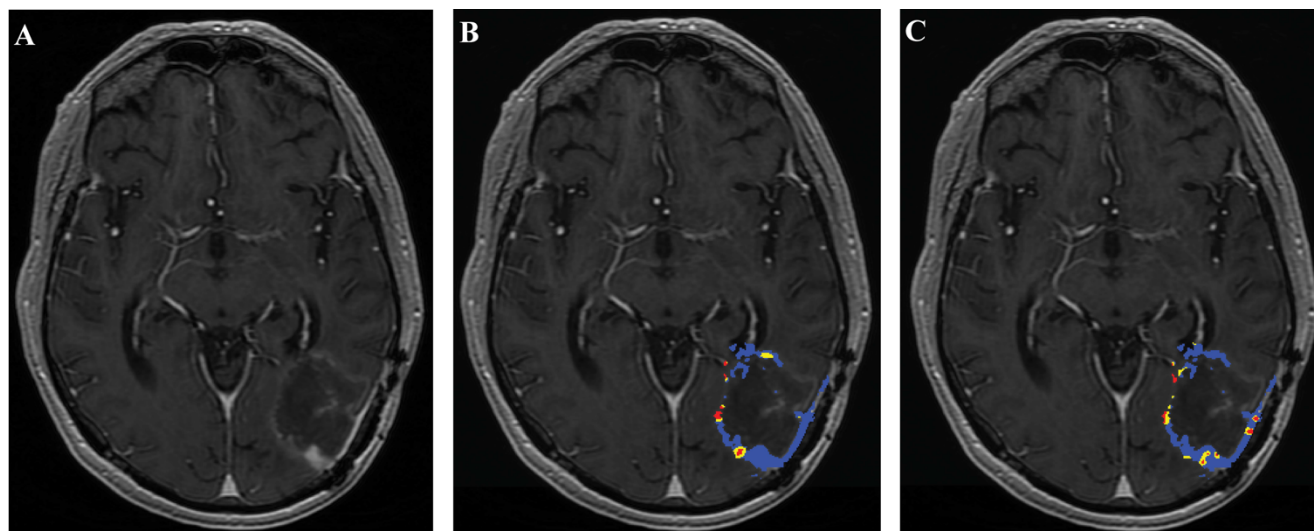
Patient (A-C) is a 62-year-old male with grade IV GM presenting 11 months after surgical resection with CCC value of 0.61 between the LFA and MFA sRCBV values. Post-contrast T1-weighted image (A), LFA FTB map (B) and MFA FTB map (C) superimposed on the post-contrast T1-image. The dice similarity coefficients comparing the LFA and MFA sRCBV for PTRE and tumor for Patient A are 0.88 and 0.46, respectively. Note the visual similarity of the maps despite low dice coefficients.
